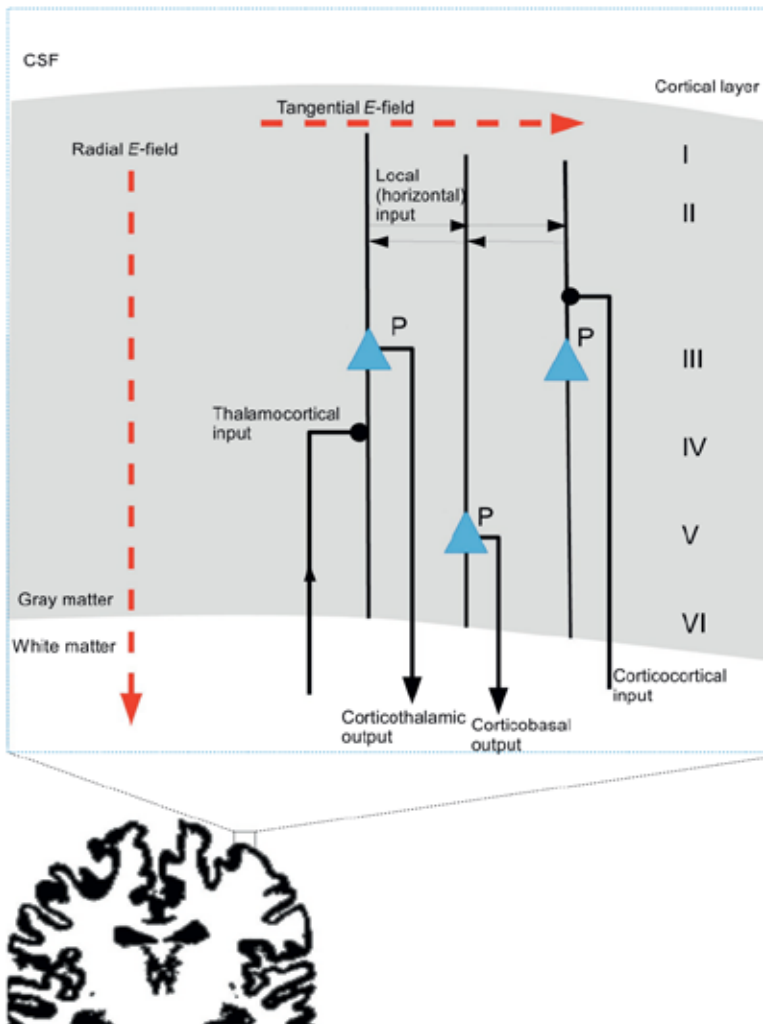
The cortical sheet is depicted below as black tissue (derived from a slice through an MRI scan segmented into a gray matter map). In the enlarged window, it is depicted how the cortical sheet consists of six layers, with pyramid cells (P), inhibitory inter-neurons and granule cells (not shown), and afferent and efferent fibers arriving from and connecting to other brain areas. The radial (perpendicular to the cortical sheet) and tangential component (parallel to the cortical sheet) of a TMS-induced incident E-field are shown as red (dark gray in the print version) arrows. For a full explanation, see Section 2.1 of Neggers et. al. 2015.
